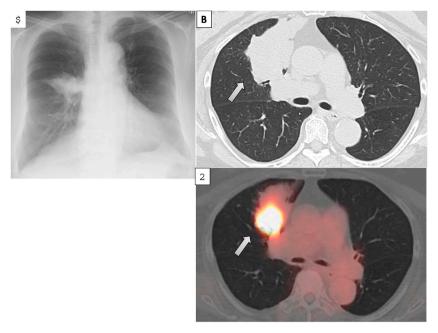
PA chest radiograph on initial presentation depicts a irregular mass-like opacity in the central right midlung (A). Axial CT chest shows a large mass-like opacity in the right upper lobe (B). PET-CT depicts abnormal FDG-accumulation of a 3 cm right upper lobe mass (C) with presumed post-obstructive atelectasis.
